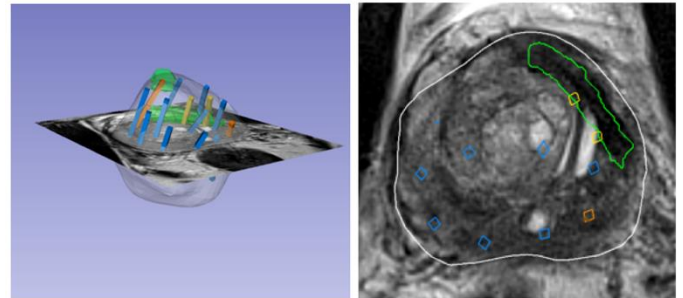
3D (left) and axial (right) image of post-FCA MRI and biopsy. Persistent apical PI-RADSv2 grade 5 lesion (green) was found with residual GG1 disease on biopsy (orange). New grade 4 left anterior lesion (green) was benign on biopsy (yellow).
